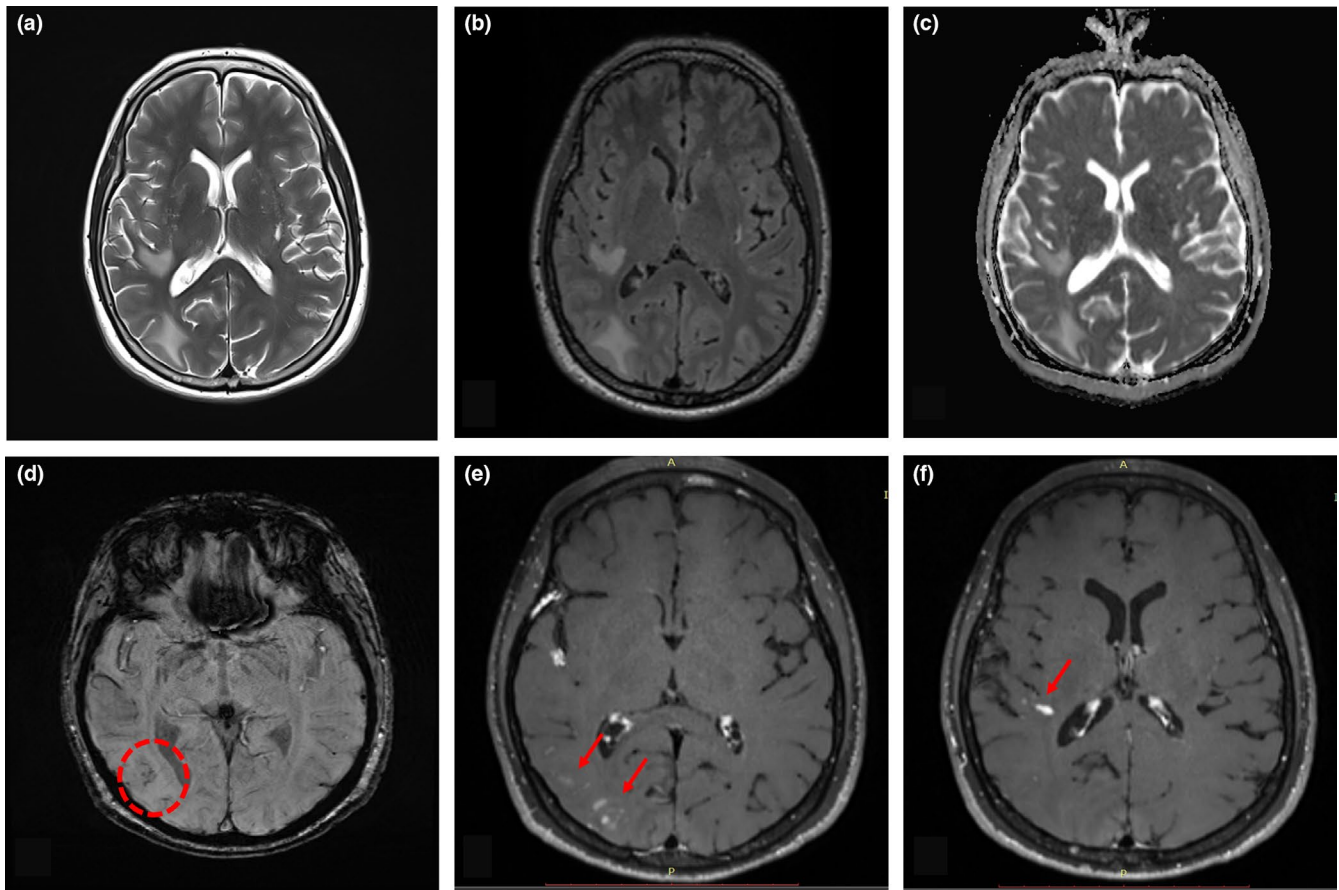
(a) Axial T2-weighted and (b) fluid-attenuated inversion recovery sequences showing reappearance of white matter hyperintensities in the right hemisphere without diffusion restriction on apparent diffusion coefficient maps (c) following corticosteroid tapering, 2 years after the patient's initial presentation. (d) Axial susceptibility-weighted imaging showing low-signal spots (dotted circle) within the lesions. (e) and (f) Axial T1-weighted images showing gadolinium enhancement of the new white matter lesions (arrows)
